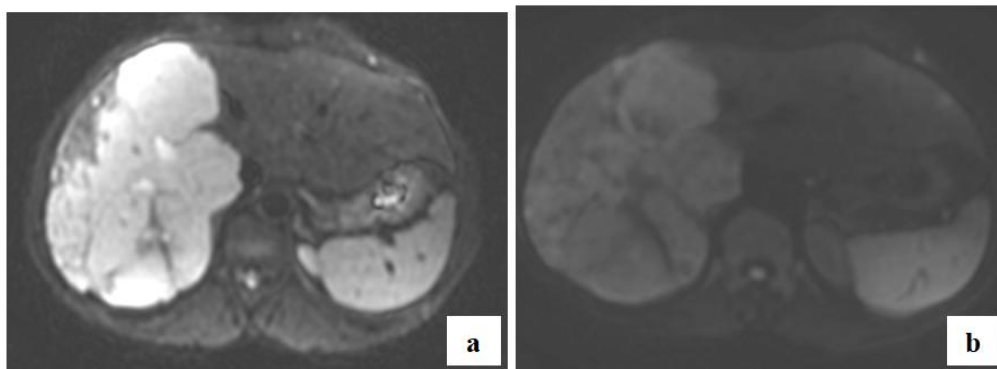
MRI axial section Diffusion sequence showing a drop in signal with increasing b value. B50 (a) B 800 (b)
